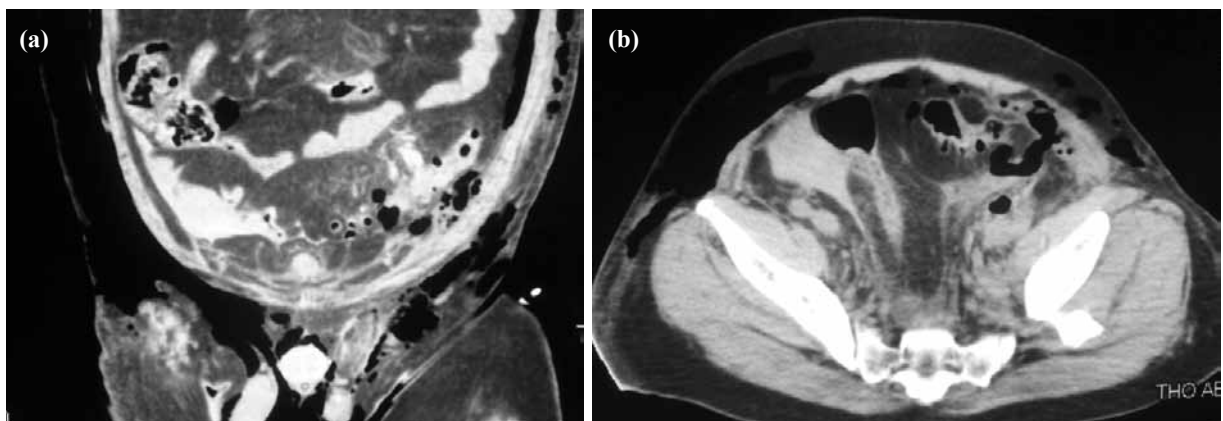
(a) (Axial) and (b) (coronal): The second computed tomography on the 3rd day of the hospitalization, free air in the retroperitoneal space and subcutaneous tissue with perforation of a sigmoid diverticulum are identified.
